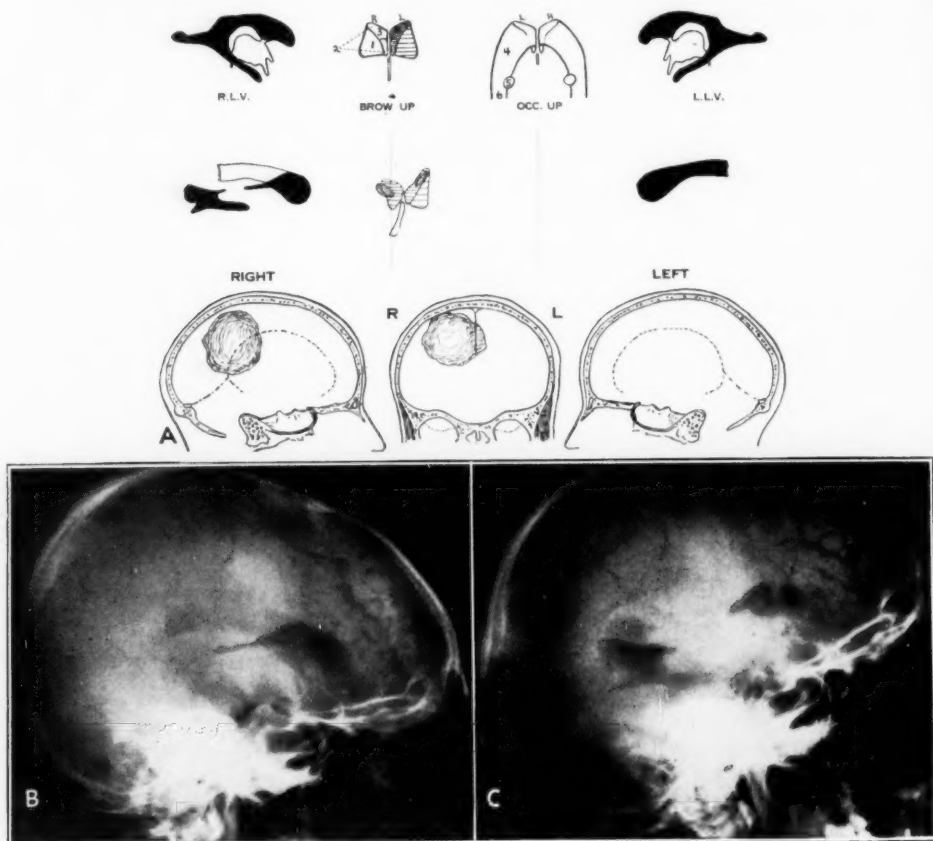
(A) Tumor of the parietal lobe extending across the midline, and (B) one of the roentgenograms used in making the tracing shown in A and (C) second roentgenogram used in making the same tracing.
